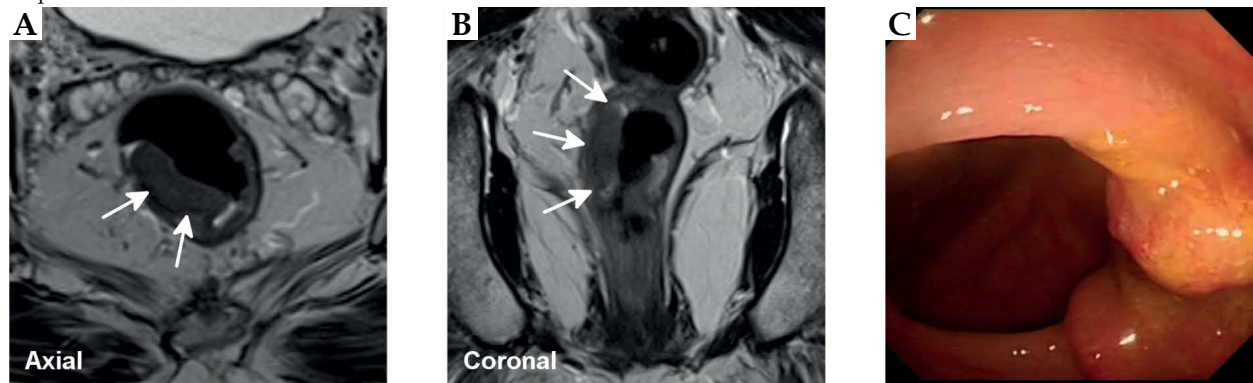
Magnetic resonance imaging (MRI) at presentation showed a T3B N0 adenocarcinoma of the lower rectum (arrows, A, B), with encroachment onto the posterior vaginal wall anteriorly seen on the axial view (arrow, A). Endoscopy revealed a polypoidal mass (arrows, C). MRI after Papillon and chemoradiotherapy showed fibrotic low signal within residual wall thickening (arrows, D, E). Flexible sigmoidoscopy at this time demonstrated a residual nodule with a central ulcer (F). Biopsy showed ulcerated low and high-grade glandular dysplasia. MRI 1-year post-transanal resection (arrows, G, H) showed no evidence of disease recurrence, with maturation of fibrosis and minimal residual wall thickening at the site of the scar. Endoscopy revealed a scar in the rectum with radiotherapy changes and no evidence of recurrence (I)
